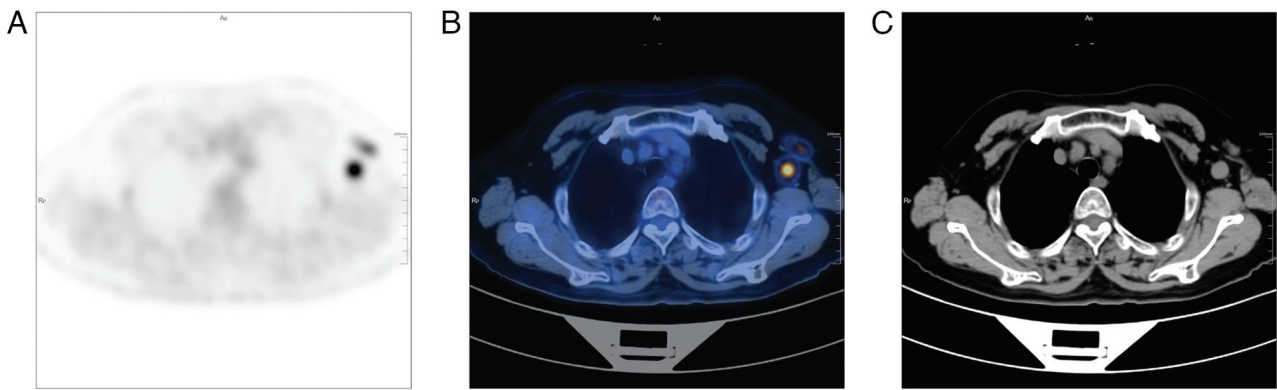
PET/CT images findings. Selected (A) PET, (B) PET/CT and (C) CT images show multiple enlarged hypermetabolic lymph nodes in the left axilla. PET, positron emission tomography; CT, computed tomography.
